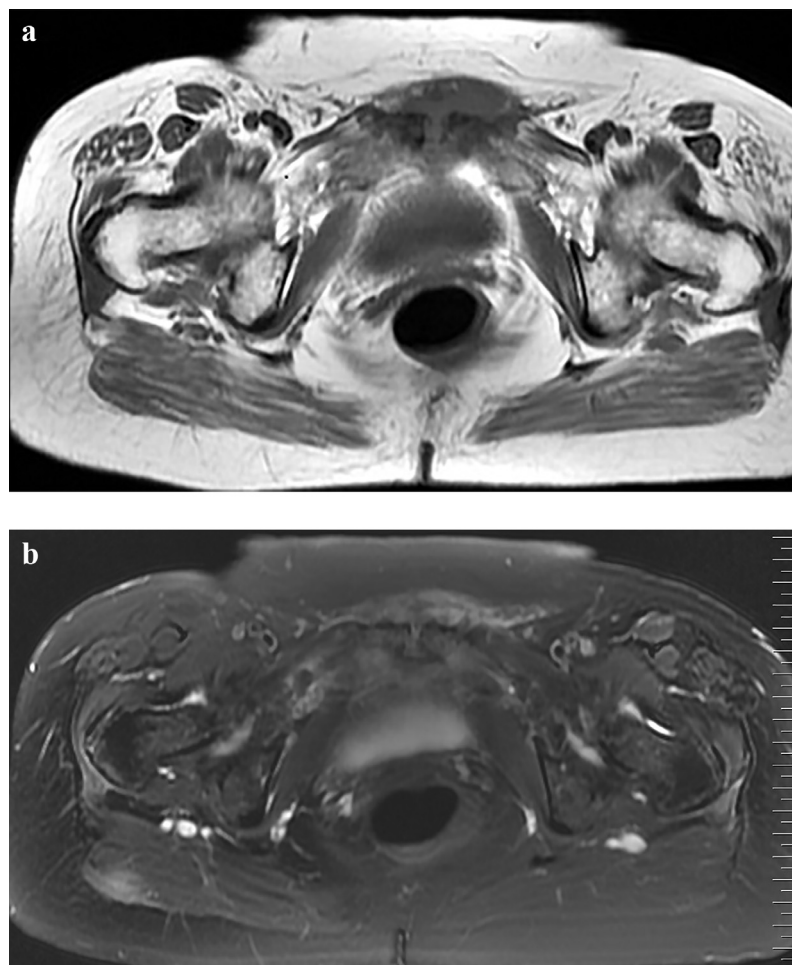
(a, b) Axial T1-weighted image (TR/TE, 500/16.5) (a) reveals low signal intensity at the subchondral marrow of the symphysis pubis, along the ischiopubic rami bilaterally and within the joint space. Axial T2-weighted image (TR/TE, 2200/81.6) with fat suppression (b) shows high signal intensity along the ischiopubic rami, within the symphysis pubis joint and extending to the soft tissues anteriorly.
